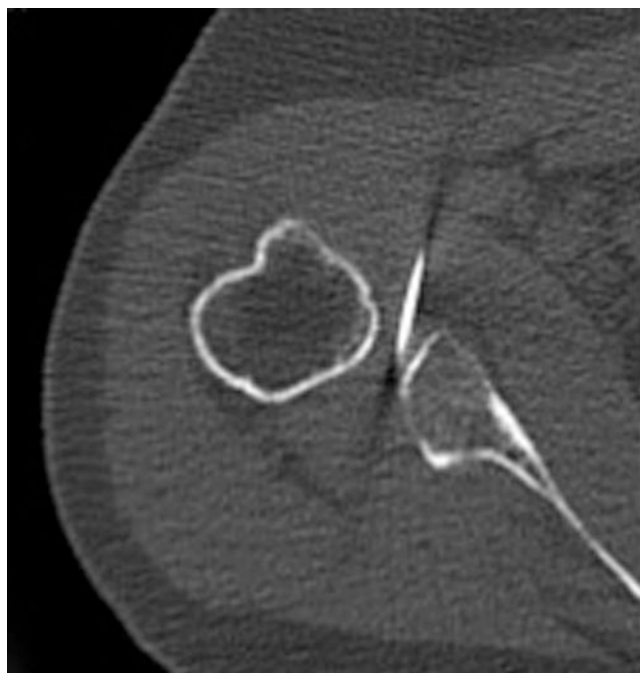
Coronal CT showing the 22G needle in articulation so that the solution composed of 2–3 ml of soluble contrast and 10–20 ml of filtered sterile air can be injected
